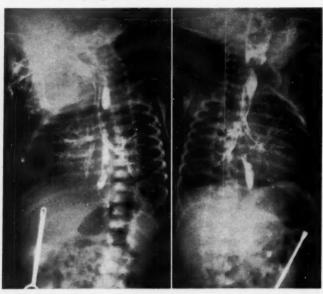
Roentgen photographs that show evidence of the typical anomaly of esophageal atresia with tracheo-esophageal fistula. The infant in this case had been given more than the usual amount of contrast medium, which resulted in exceptionally clear outlines of the tracheobronchial tree and lower esophageal segment. Note the blind upper esophageal pouch filled with contrast medium; also the lower esophageal segment leaving the mid-tracheal region. There is evidence of considerable gas present in the gastrointestinal tract, which is proof that the distal esophagus communicates with the trachea.
